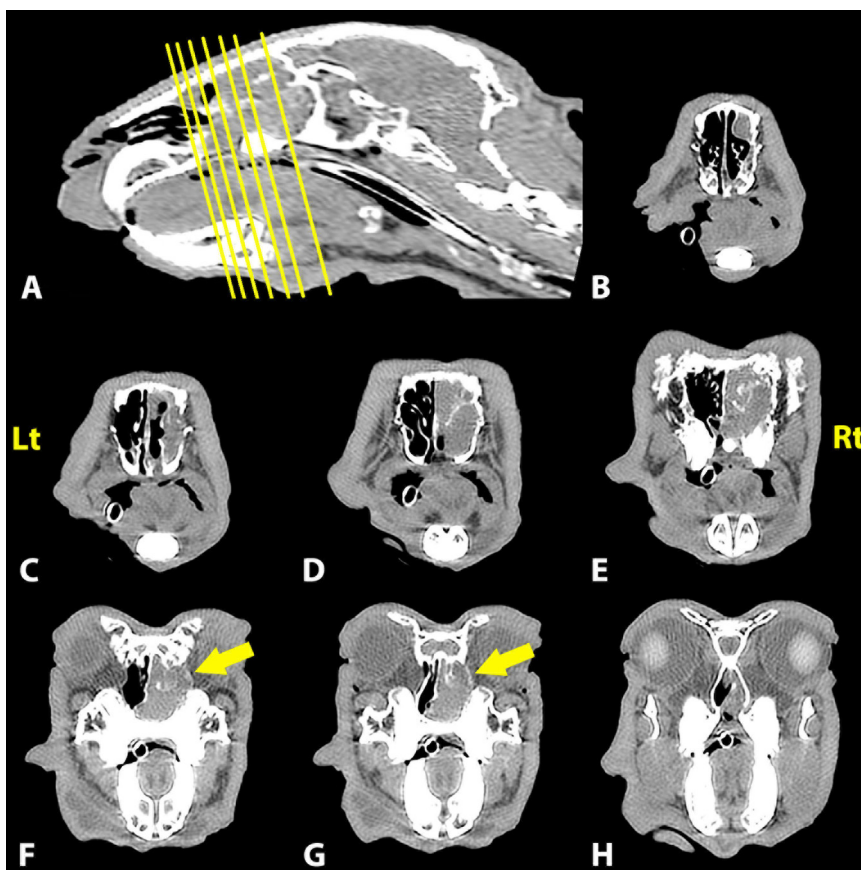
Computed tomography of the skull, lateral (A) and axial (B-H); soft tissue window. (A) Lateral view image, paramedian of the right side corresponding to the longitudinal section of the right mandibular incisor tooth. Yellow lines represent the scanning planes of the axial views. (B-H) Axial view image, showing radiodense material filling the nasal meatuses and recesses of the right nasal cavity, at the level of the ventral nasal concha (B and C), maxillary recess (D), maxillary cheek teeth arcades (E-G), and rhinopharynx (H). Asymmetry and deviation of the nasal septum (E-H) and lysis of the pterygoid bone along the medial aspect of the left orbit (F and G; arrow) are also visible.
